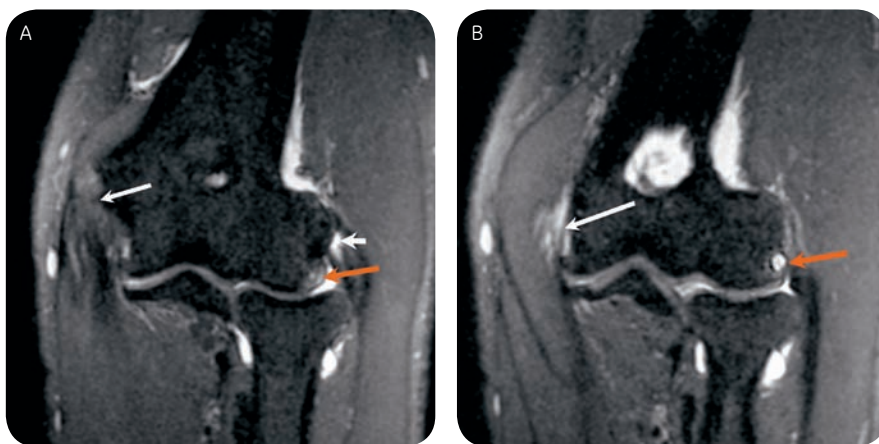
Coronal 3D Cube, T2-weighted Fast Spin Echo FatSat showing lateral epicondyle bone abnormalities in favor of cortico-periosteal lesions, in similar conditions as conventional coronal 2D T2-weighted Fast Spin Echo sequence. The different reformat planes are showing a hypersignal fluid type that reaches the deep margin of the common section of the lateral and medial epicondylar tendons, in favor of a partial tear (white arrows).
